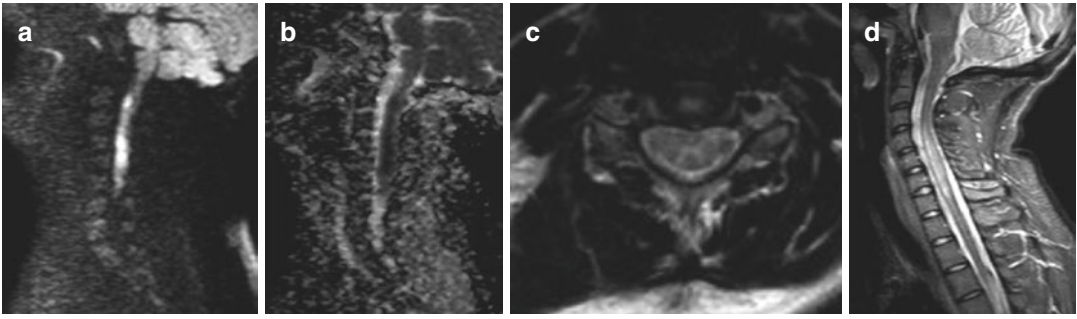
(a) Sagittal DWI and (b) sagittal ADC images demonstrate restricted diffusion in the cervical cord with corresponding T2 hyperintense signal seen on (c) axial
